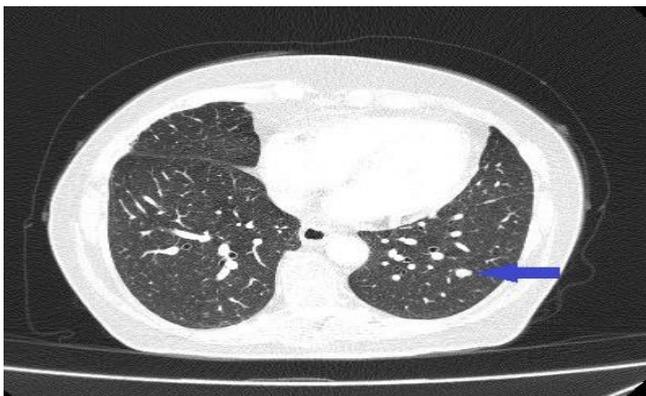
Thorax computed tomography showing a 6x8 mm nodule in left lung lower lobe
